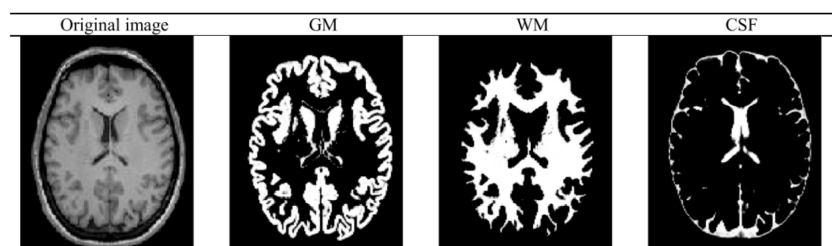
Segmentation of a brain MRI into gray matter (GM), white matter (WM), and CSF by Statistical Parametric Mapping (SPM) [2].
